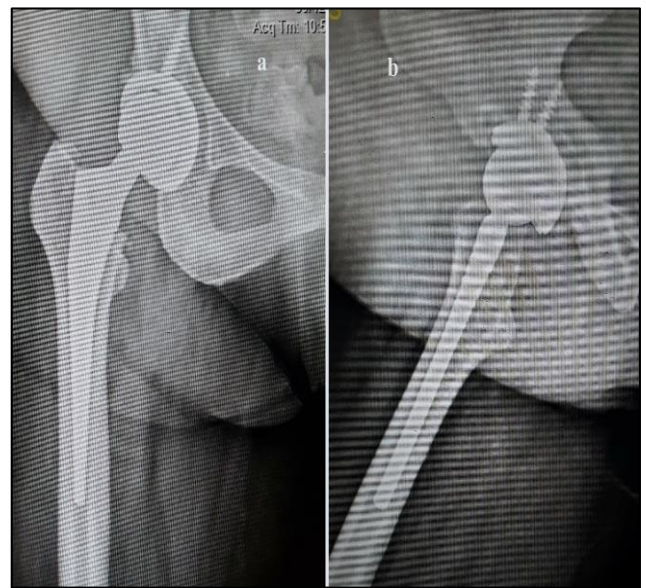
(A and B): Antero-posterior and lateral view radiograph of the right hip with uncemented hip prosthesis in situ.
